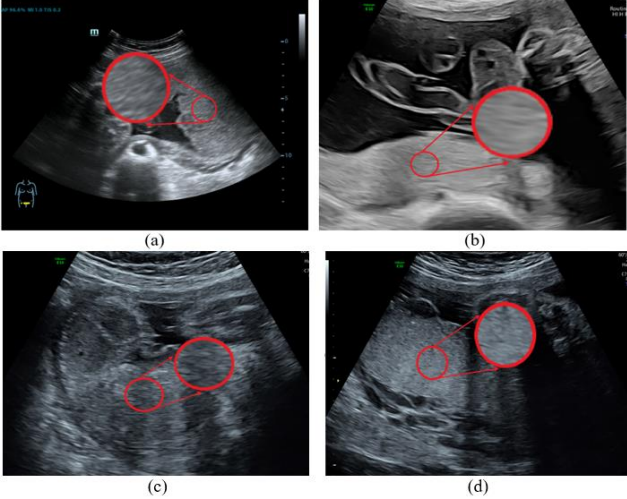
Sample of placental ultrasound images. (a) and (c) are placental ultrasound images with FGR, (b) and (d) are normal placental ultrasound images.
